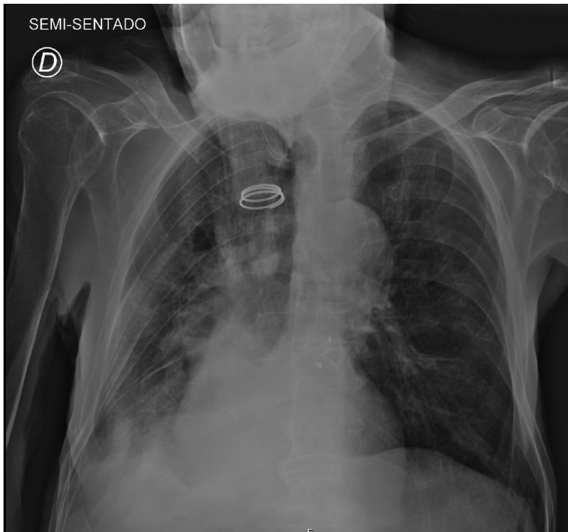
Chest X-ray 48h hours later.
